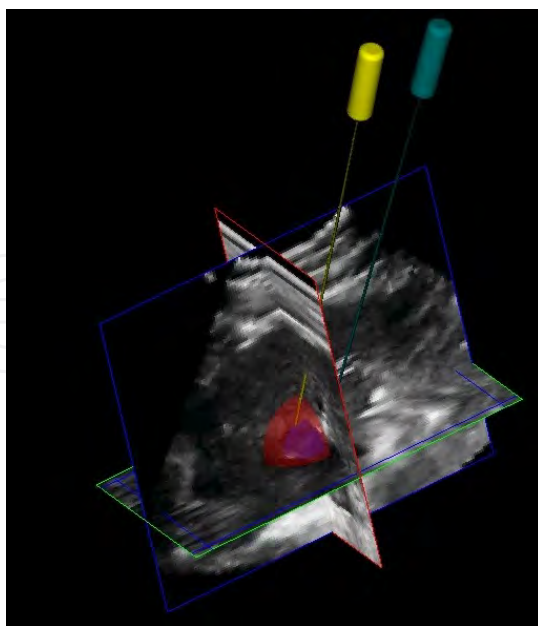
3D ultrasound image of a primary (hepatocellular) tumor with two microwave applicators in place. The applicators and tumor have been segmented and displayed in 3D allowing the interventional radiologist to examine the placement accuracy of the applicators in the tumor. In addition, the ablation zone has also been superimposed.
